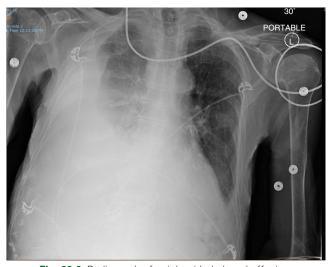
Radiograph of a right-sided pleural effusion.
